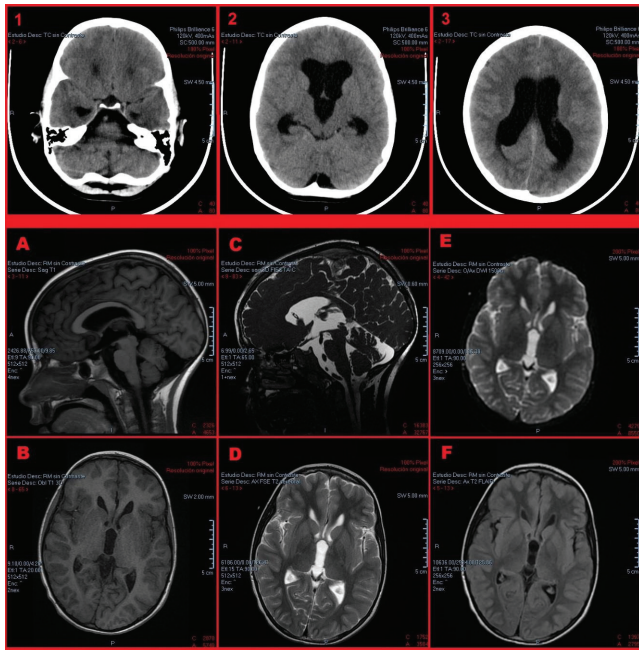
CT and MRI. CT scan prior to placement of DVE (1,2 and 3): Signs of hypertensive hydrocephalus affecting both lateral ventricles (with contour bulging of frontal and temporal antlers) and the third ventricle are observed. The fourth ventricle shows no apparent dilation. No space-occupying injuries are appreciated. Ultra-thin MRI performed after DVE placement: The multiple sequences performed are observed: T1 (A and B), T2 (D), 3D-FIESTA (C), FLAIR (F) and diffusion (E). The cyst content is isointense with respect to the CSF in all sequences. In image C, the anterior, posterior and superior limits of the cyst of the third ventricle are observed with submillimeter precision.
